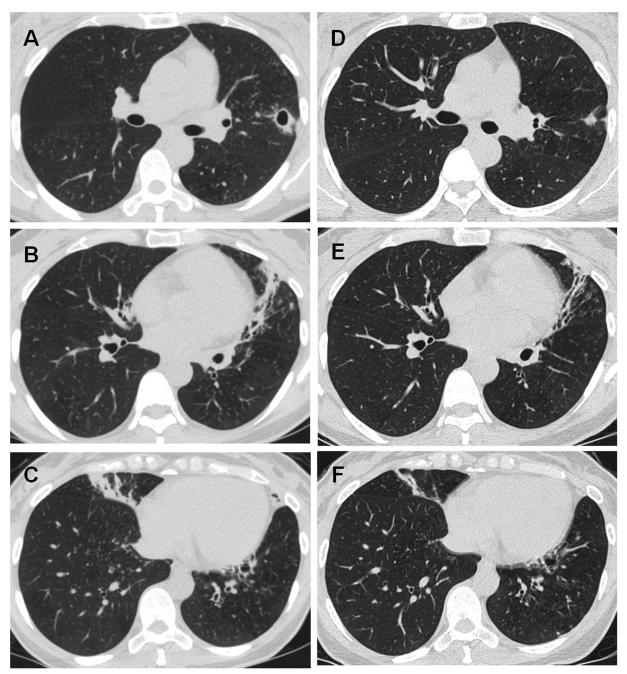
Forty-three-year-old woman with *M. massiliense* lung disease. Computed tomography showed extensive bronchiectasis and peribronchial consolidation in both lungs. (A to C) There was also a 17-mm cavity in the left upper lobe. (D to F) After 12 months of oral antibiotic therapy, the cavity in the left upper lobe was obliterated and the peribronchial consolidation decreased markedly.
